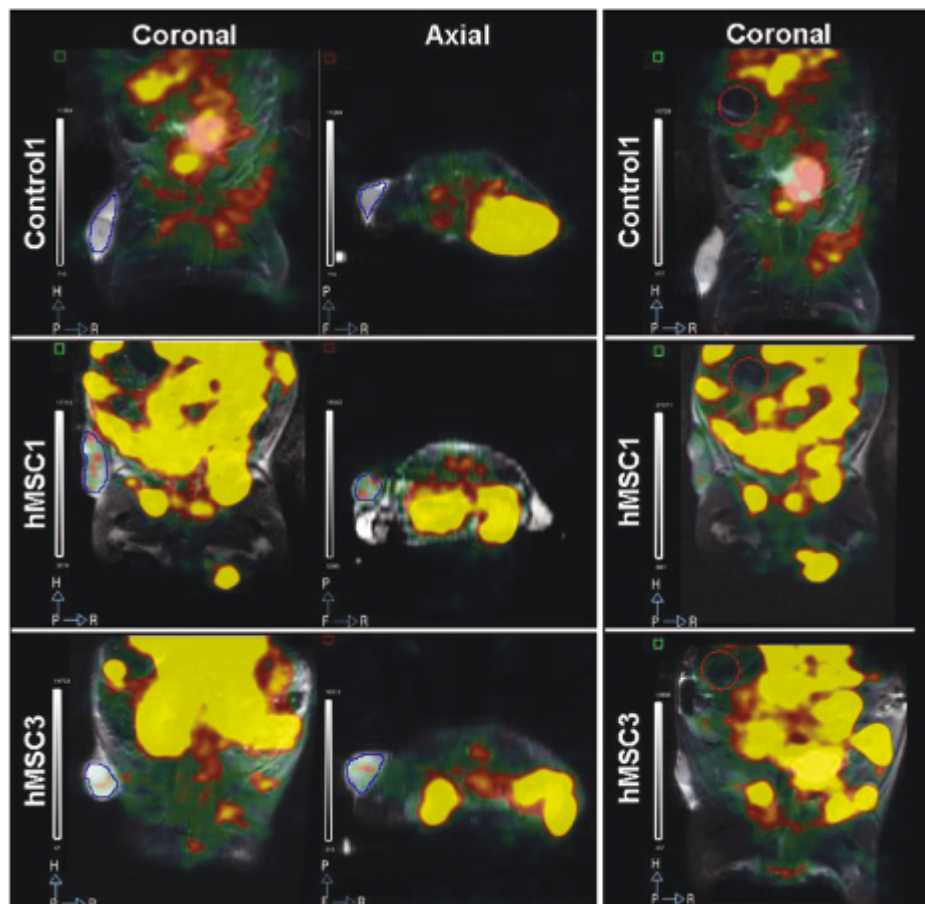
Example of region of interest (ROI) delineations on the coregistered MRI/SPECT images. *Left to right:* coronal and axial view of the tumor (*blue ROI*) and coronal view of the abdomen (*red ROI*). hMSC = human mesenchymal stem cell.
